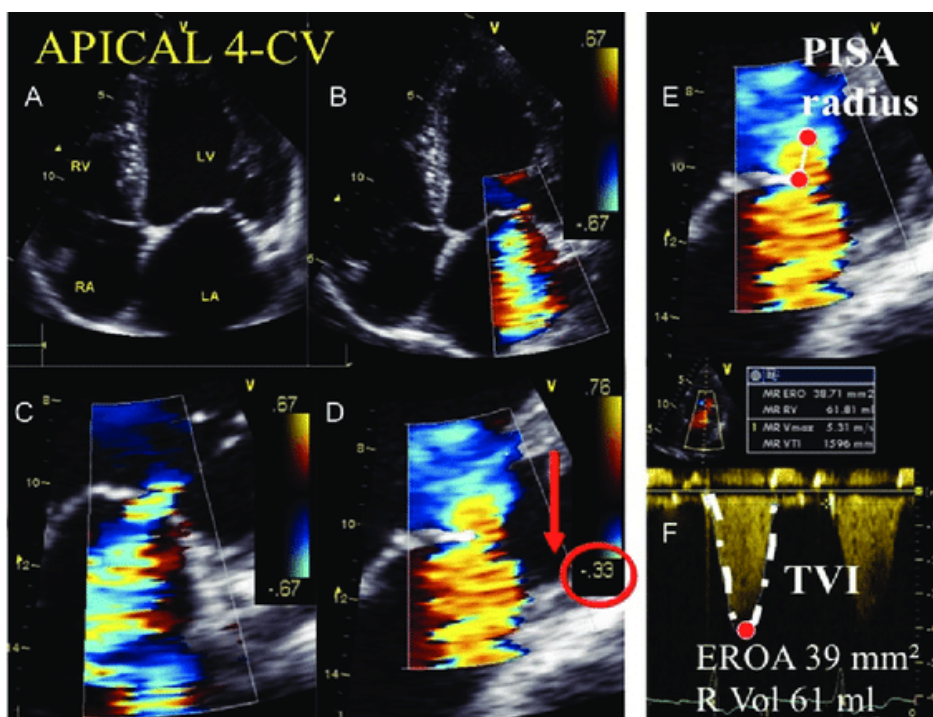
Employing the PISA approach to quantitatively quantify the severity of MR. Step-by-step MR analysis: A hemispheric PISA is obtained by shifting the zero baseline lower; (B) colorflow is displayed; (C) the select zone is zoomed in; (D) the apical four-chamber view (CV) is measured using the first aliasing; (F) MR jet continuous wave Doppler that enables the determination of the regurgitant volume (R Vol) and effective regurgitant orifice area (EROA). Time-velocity integral, or TVI. Source: Adapted from Lancellotti et al. (2013).^[243]
